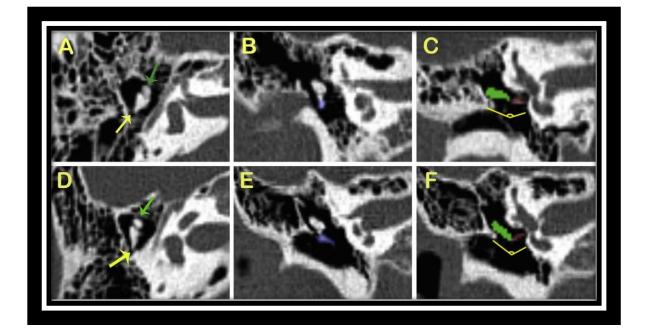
Representative HRCT images of the ossicular chains in ears in with (CAS; A-C) and normal ears (D-F). (A and D) The size of the malleus head (green arrows) and the length of the short process of the incus (yellow arrows). (B and E) The length of the malleus handle (blue). (C and F) The length of the long process of the incus (green) and the angle of the incudostapedial joint (yellow). The red bones in C and F are stapes (Li et al., 2017).
